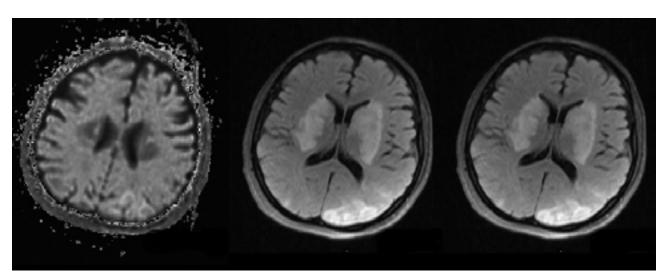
The brain diffusion MRI, hyperintense in the ADC and T2 sequences, diffusion was restricted in both basal ganglia and the left occipital lobe
